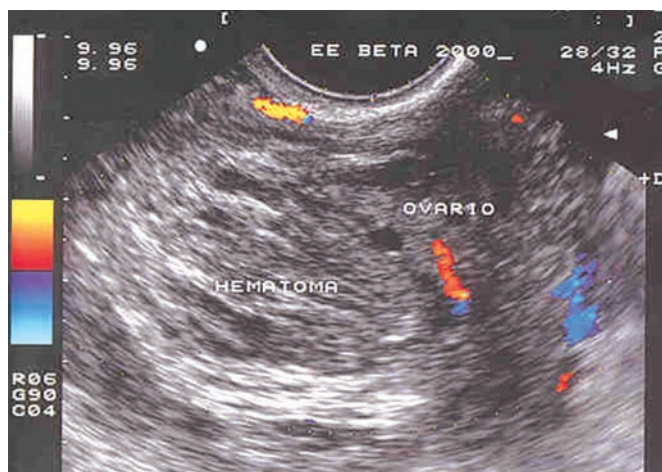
Rupture of an ectopic pregnancy (ultrasound findings type 5). An important hemoperitoneum is visible, with clots.
